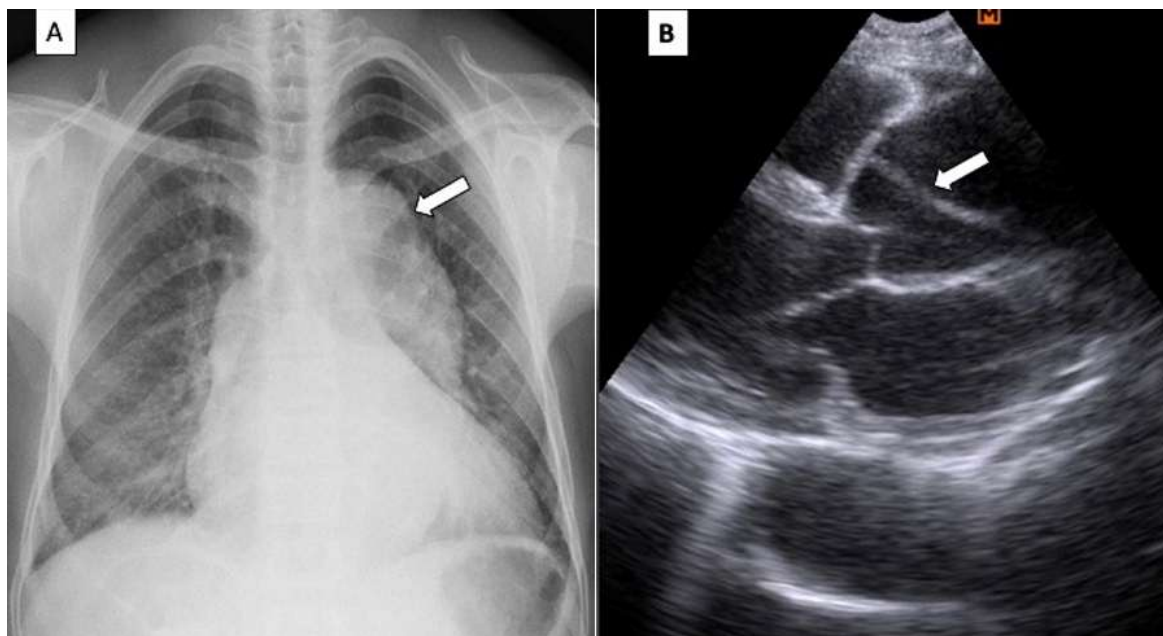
(A) chest X-ray with thoracic aortic aneurysm and (B) echocardiogram with image of flap, compatible with dissected aortic aneurysm
